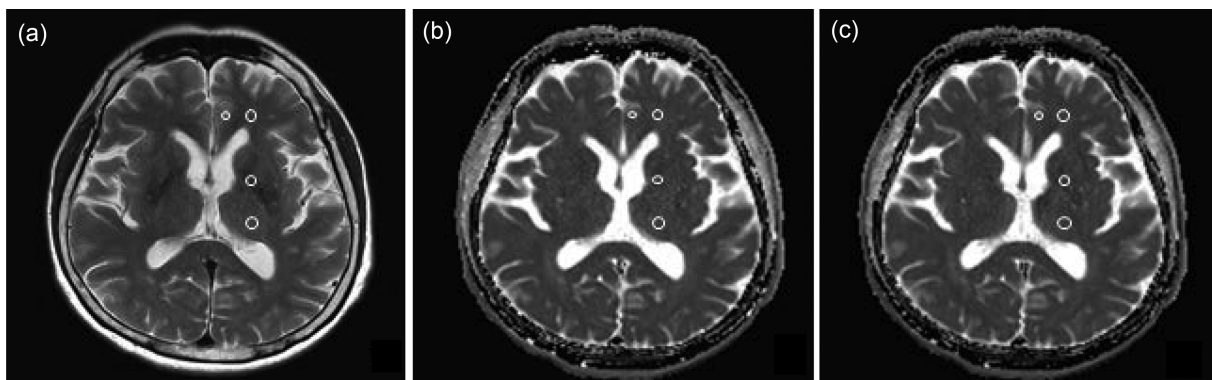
MR image shows ROIs were set at locations of white matter, gray matter, thalamus and globus pallidus on T2 weighted image (a), ADC_{2 b-value} image (b) and ADC_{4 b-value} image (c) respectively.
